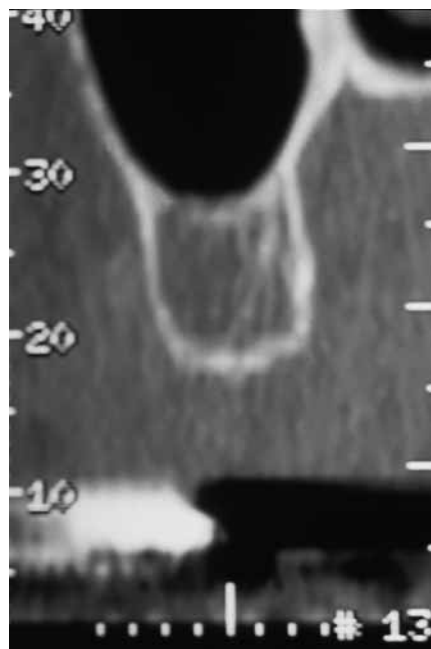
Oblique CT scan cut showing a low density bone (type IV).
